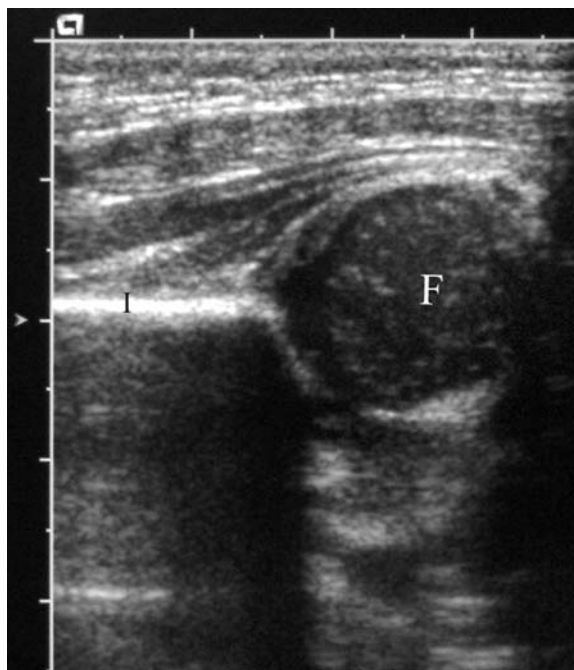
Longitudinal sonographic view of a normal infant hip: the cartilaginous femoral head (*F*) is positioned in the acetabulum. *I*, ilium
